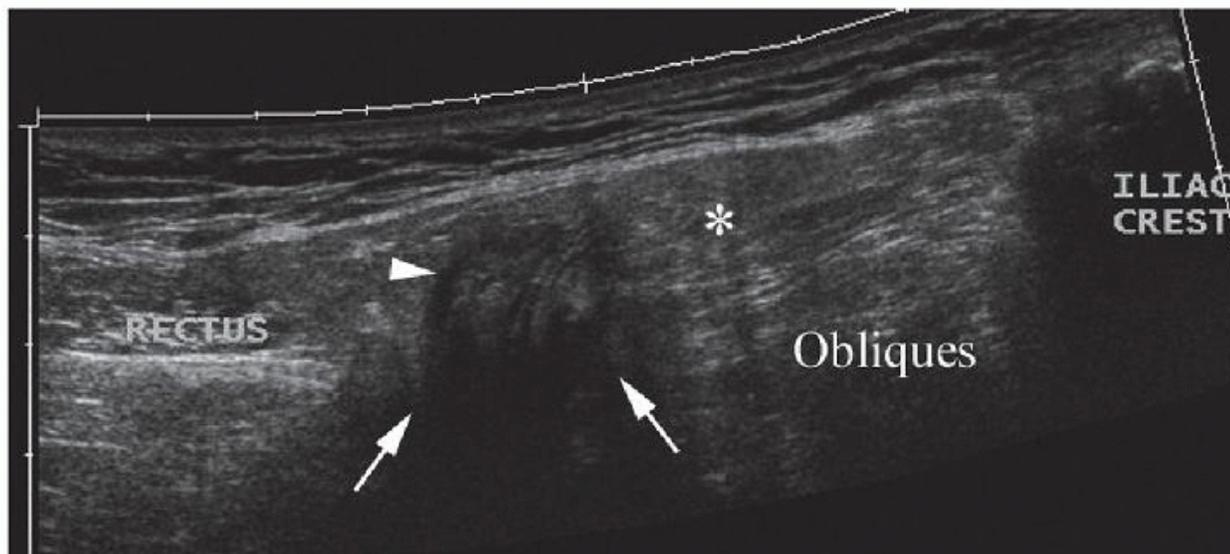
Spigelian hernia. Transverse sonogram shows Spigelian hernia of fat (asterisk) and edematous fat (arrowhead) emerging through the Spigelian fascia (arrows) between rectus and the oblique muscle group.
